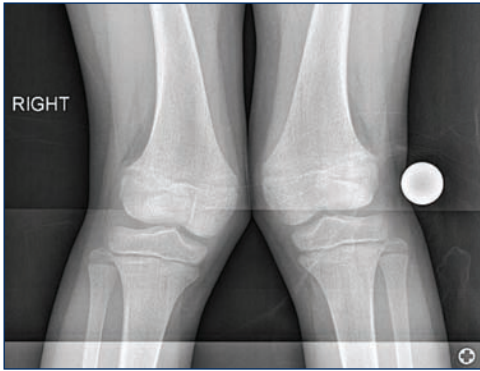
Preoperative AP radiographs of the knees showing genu valgum deformity
